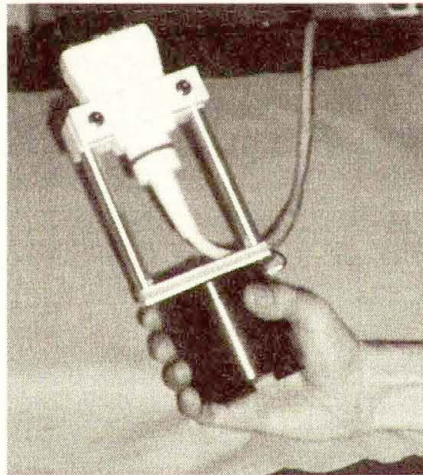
Improvement of the mechanical system for preliminary clinical investigations in breast cancer detection : Ultrasonic probe mounted on the low frequency *vibrating* device
